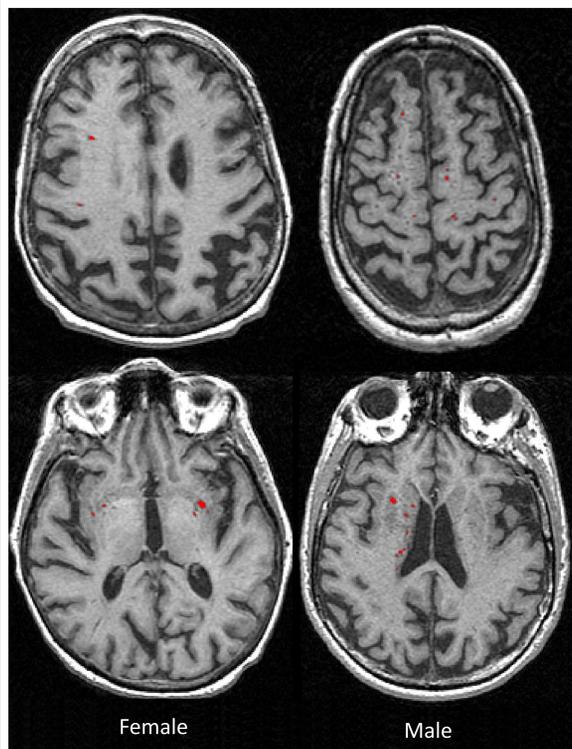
Semi-automatically segmented perivascular spaces (red) overlaid on a structural T1-weighted MRI of a female (left) and male (right) brain.
